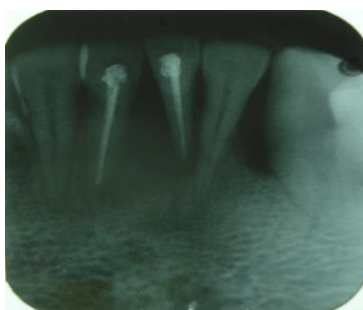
One year post-operative radiograph with increase radioopacity with 31 suggestive of regeneration
